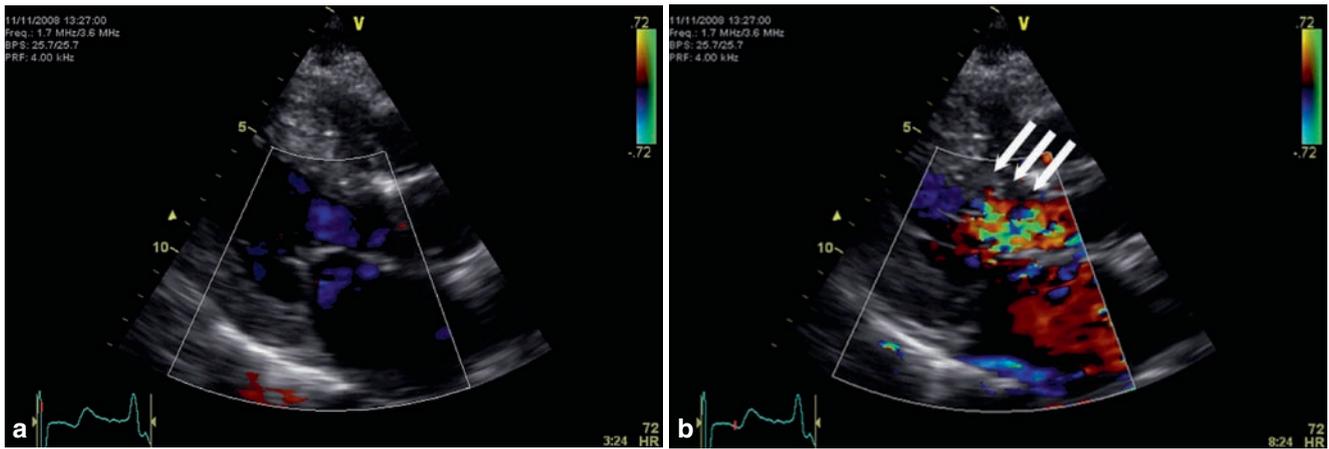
Parasternal long-axis view in hypertrophic obstructive cardiomyopathy. (a) End-diastolic frame for orientation. (b) Colour Doppler mapping in systole shows flow acceleration and turbulence in the LV outflow tract, well proximal of the aortic valve (arrows)
